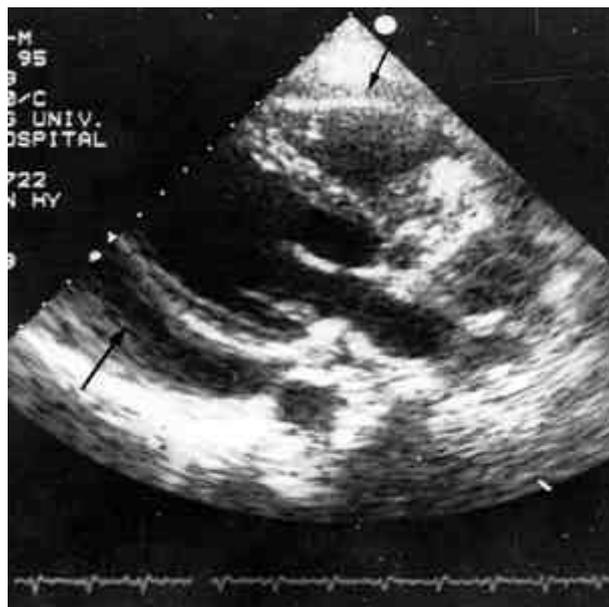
Echocardiogram, long-axis parasternal view demonstrating massive pericardial effusion. The arrows point to pericardial effusion.
